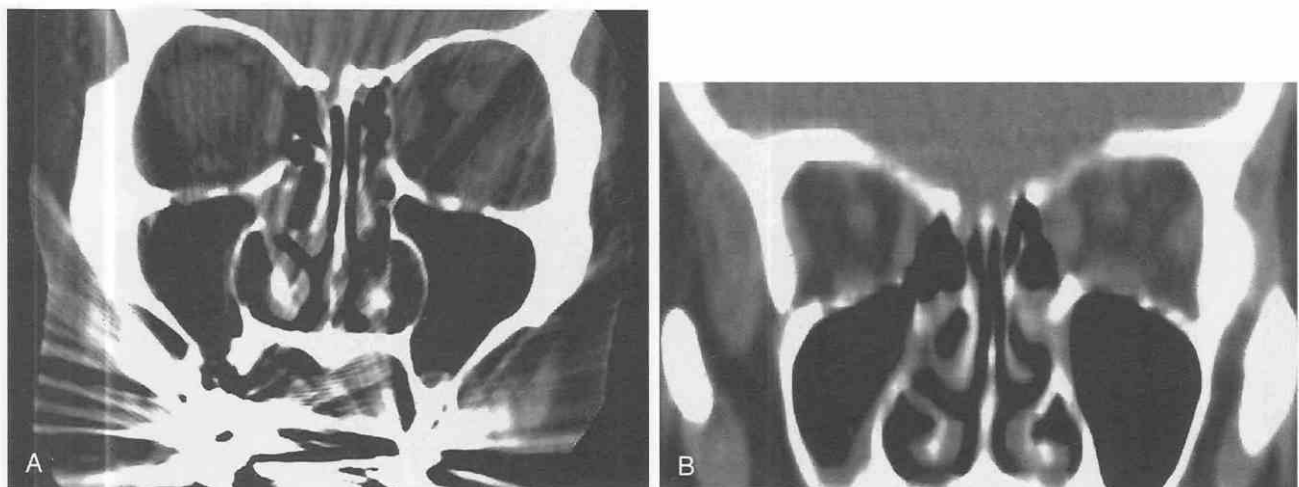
A, Coronal CT scan in a patient whose extensive dental hardware obscures detail in the orbits. B, Reformatted coronal view shows enlargement of the extraocular muscles on the left side. In view of the patient's known hyperthyroidism, this finding was thought to represent Graves' disease.
